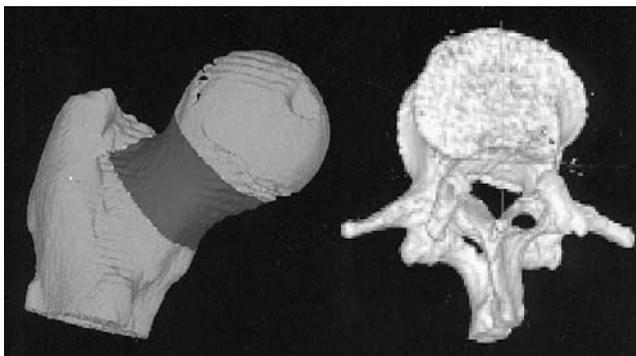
Three-dimensional representation of the lumbar spine and the proximal femur from 3D or volumetric CT acquisition. The lumbar spine and the proximal femur were encompassed with 3-mm contiguous slices, and segmentation was obtained by mapping the bone surface using a contour-tracking algorithm. (See also color plate.)
